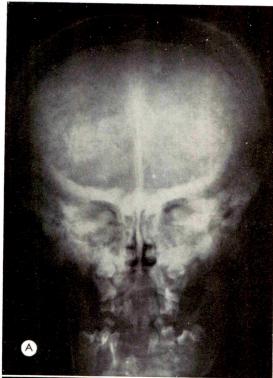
In cleidocranial dysostosis the skull is cubeshaped as shown on this roentgenogram. The vault is thin and the fontanels have remained open. Wormian bones could be seen on the original roentgenogram. The maxilla is underdeveloped and the antra are small. Supernumerary teeth are present.
